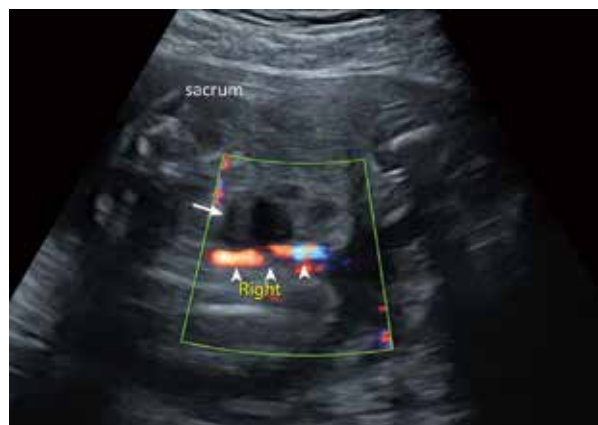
A sonographic image of the umbilical cord at 25 and 5/7 weeks of gestation. Right umbilical artery (arrowheads) is present around the urinary bladder (an arrow), whereas left umbilical artery is absent.
